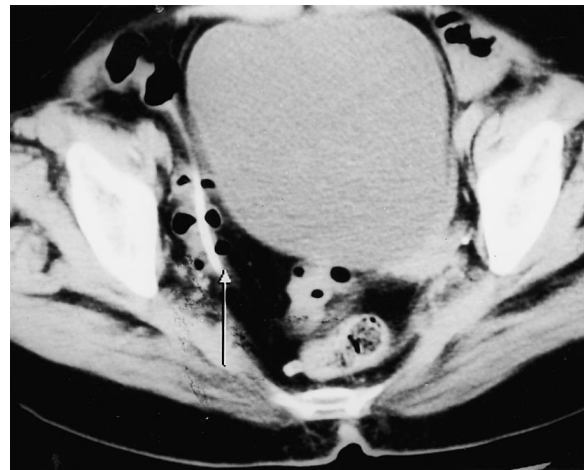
CT of the pelvis demonstrating the tip of the shunt catheter within the sigmoid colon (arrow).
